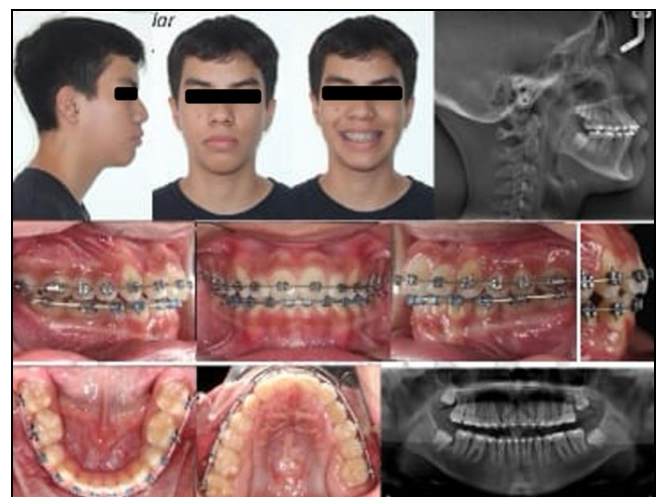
Photographs and radiographs after 8 months of orthopedic and orthodontic treatment
